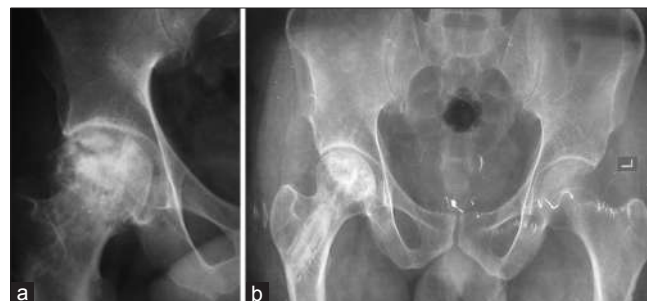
(a) X-ray (R) hip joint anteroposterior view showing advanced stage osteonecrosis of hip treated with vascularized fibular graft, (b) X-ray pelvis both hip joints anteroposterior view (b) after 11 years showing the lesion has healed and femoral head has maintained the sphericity
